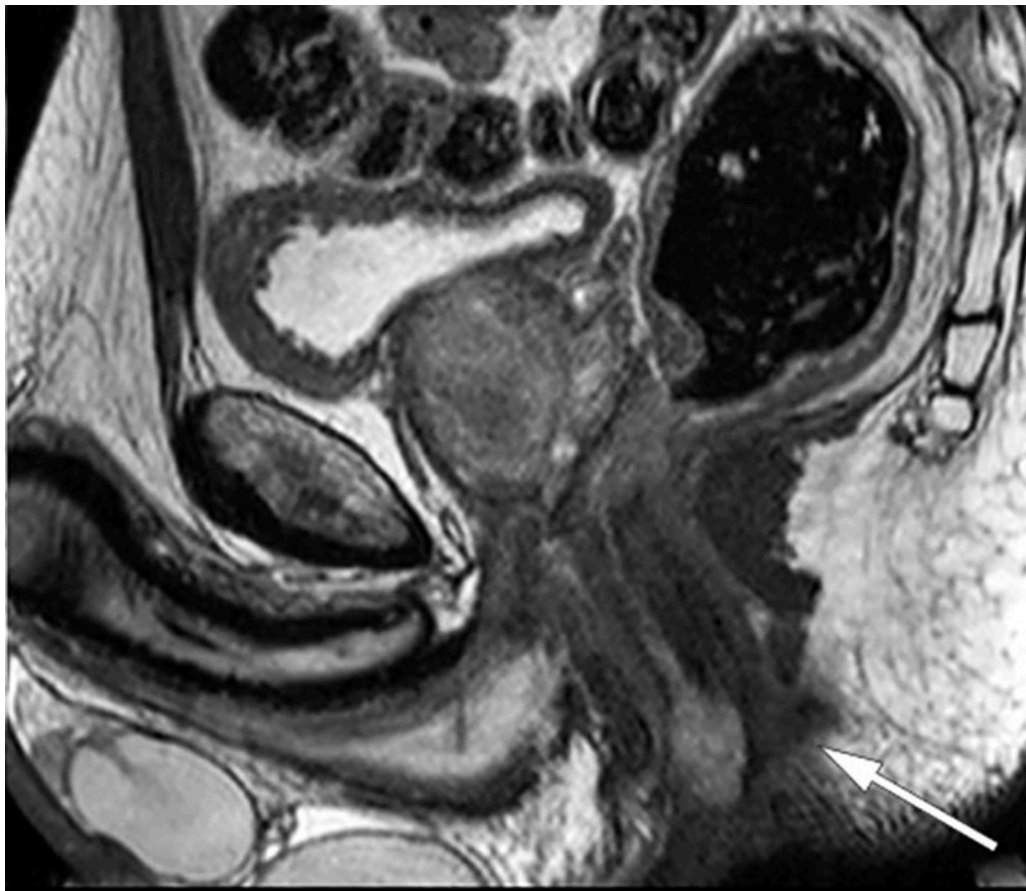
MRI, sagittal view of pelvis. Tumour can be seen in the lower anal canal (arrow).
